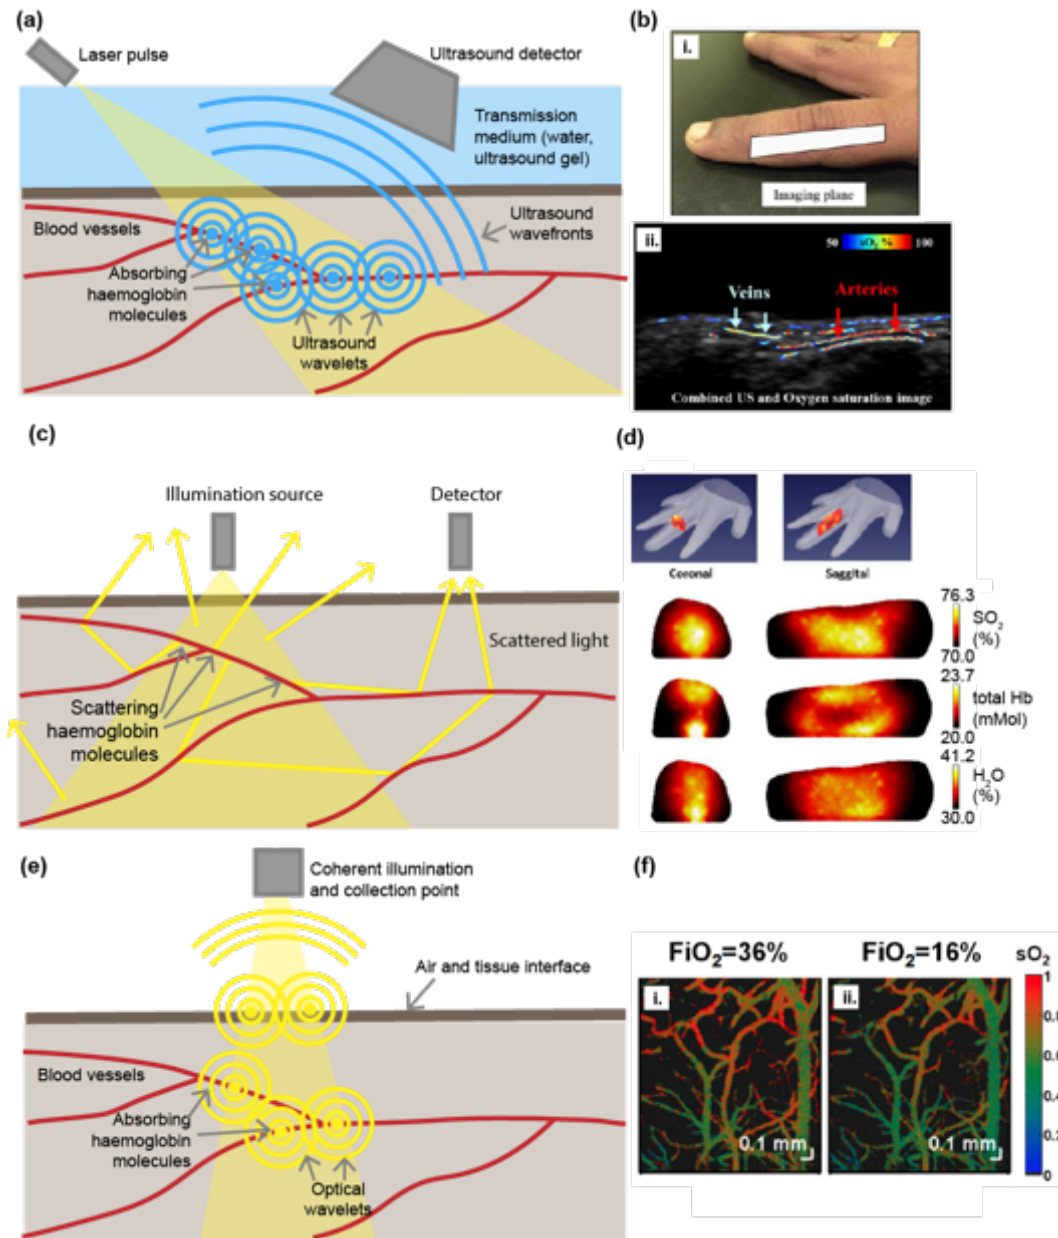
Principles of depth-resolved imaging. (a) In photoacoustic imaging, the absorption of light pulses generates a broadband acoustic wave detected at the tissue surface by an ultrasound transducer. (b) Photoacoustic imaging of oxygenation of the finger in combination with ultrasound to image the veins and arteries.¹⁴⁷ (c) In diffuse optical imaging (and diffuse
